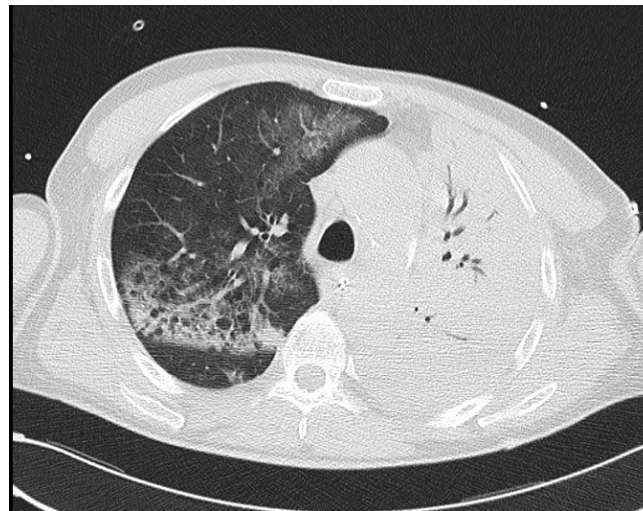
Computed tomography of the chest before starting non-invasive ventilation.
